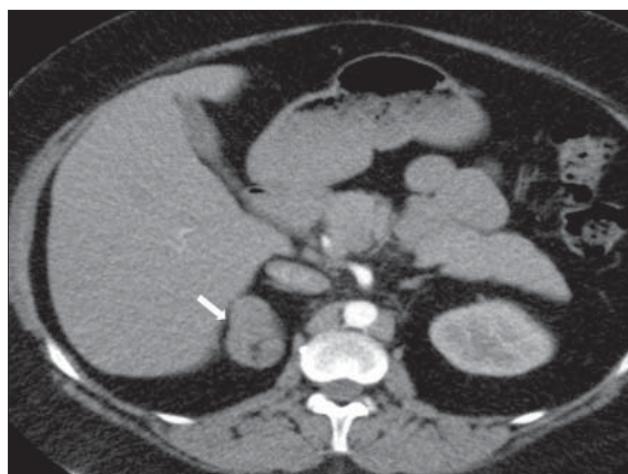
Axial view of adrenal CT of the patient. The arrow shows a 5 cm right adrenal mass.
